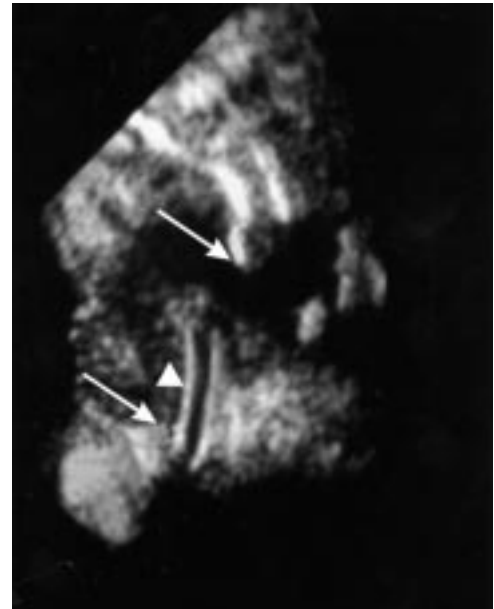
Ultrasonogram of a postoperative anastomosis at 2 weeks (case 11, right side), showing vertical limits of 11.3 mm (arrows). A part of the silicone intubation (arrowhead) is seen to pass inferiorly through this plane of section.
